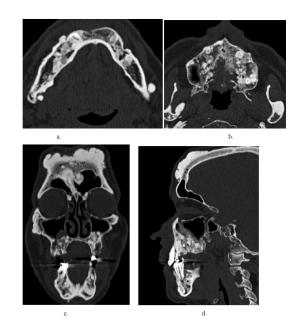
(case 1). Multiple osteomas in a 55-year-old patient with Gardner syndrome. Multiple osteomas in the maxilla, mandible, and cranial bones in a patient with Gardner syndrome in (a and b) axial, (c) coronal, and (d) sagittal maxillofacial computed tomography examination.
